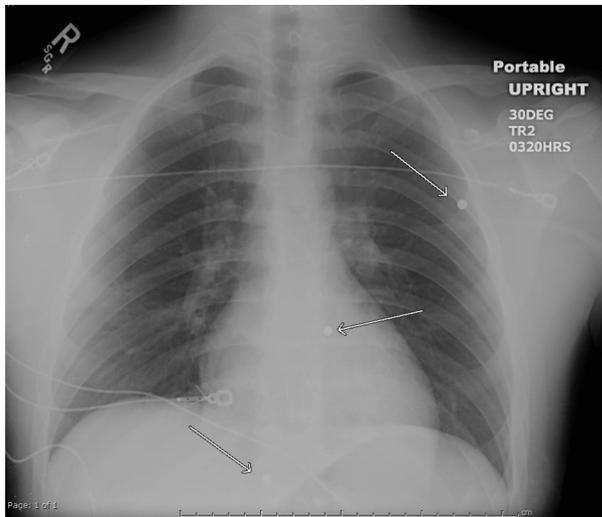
Chest roentgenogram reveals multiple foreign bodies (arrows), including the pellet overlying the cardiac silhouette. There is no notable hemopneumothorax or widened mediastinum.
